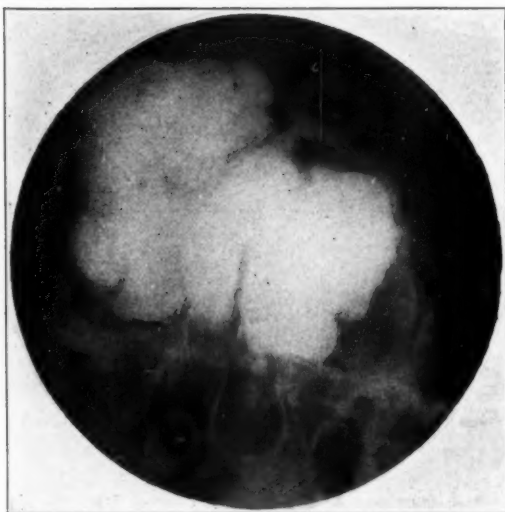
(Case A327297). Roentgenogram showing an osteosarcoma involving both orbital cavities.
